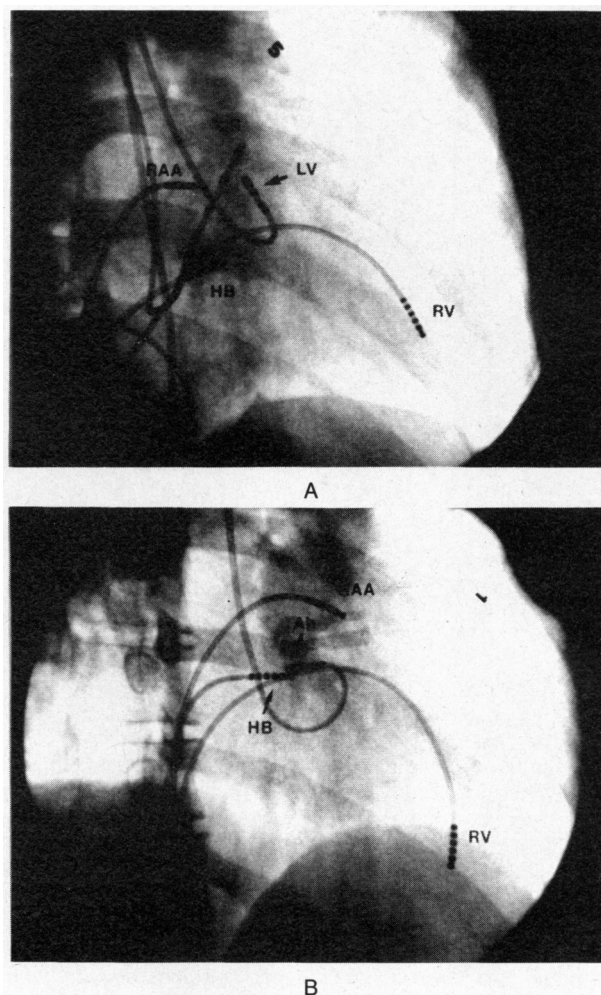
Catheter-Electrode Positions for Accessory-Pathway Ablation (Radiographs in 30-Degree Right Anterior Oblique Projection).
